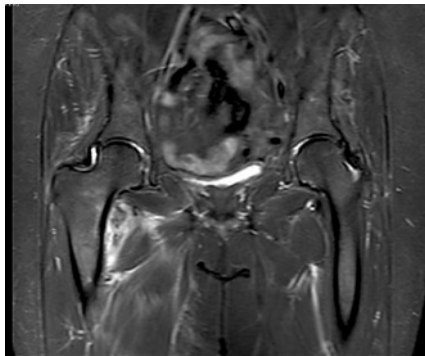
Coronal MRI STIR images of the pelvis showing infiltrative marrow metastasis.
